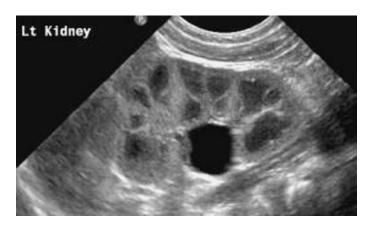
Renal ultrasound showing longitudinal image of the left kidney with mild dilatation of the renal pelvis.
